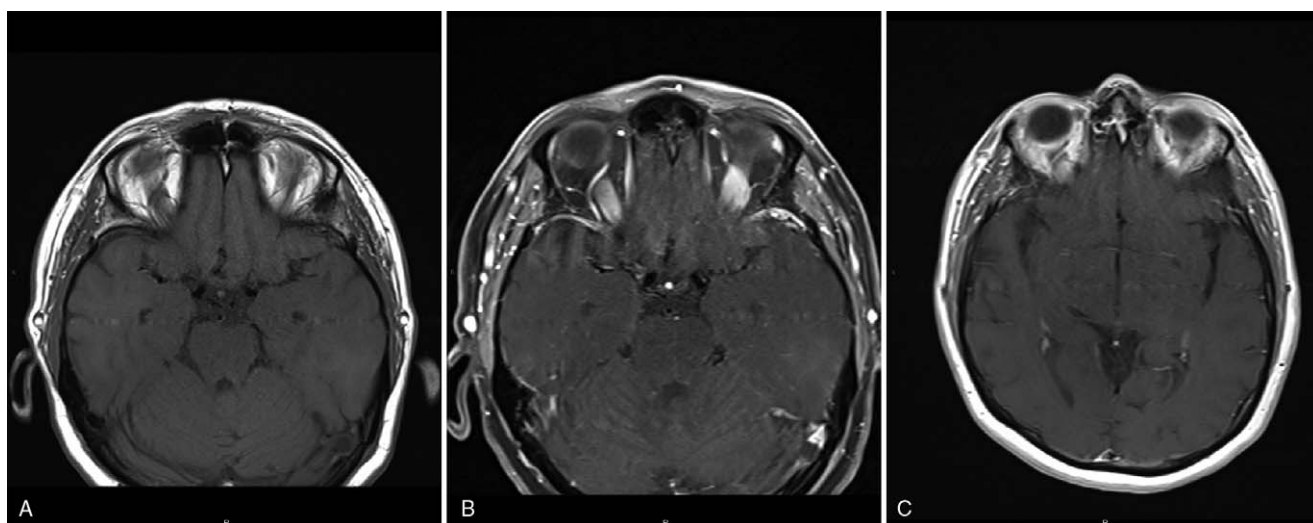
A–C, Axial 3T MRI T1-weighted postgadolinium axial images demonstrating enhancement of the left greater than right olfactory bulb and bilateral olfactory tracts.
